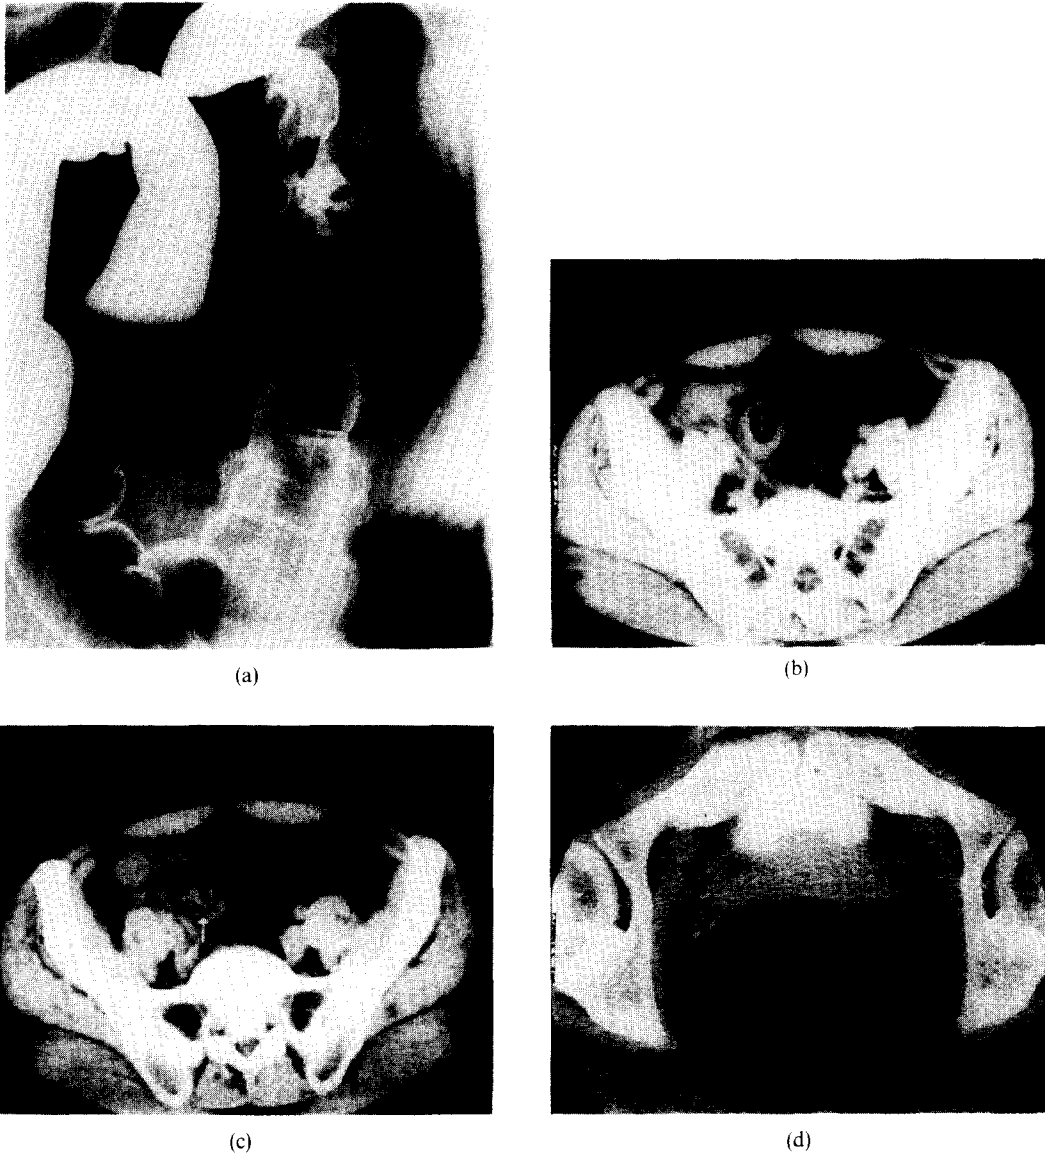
Case 3; air contrast barium enema (a) demonstrates an ulcerating lesion in the distal sigmoid (arrow). CT (b) shows annular thickening of the bowel wall at this level (arrow) and in (c) air (lower arrow) that is submucosal. Normal thin wall of the rectum (d) is shown for comparison.
